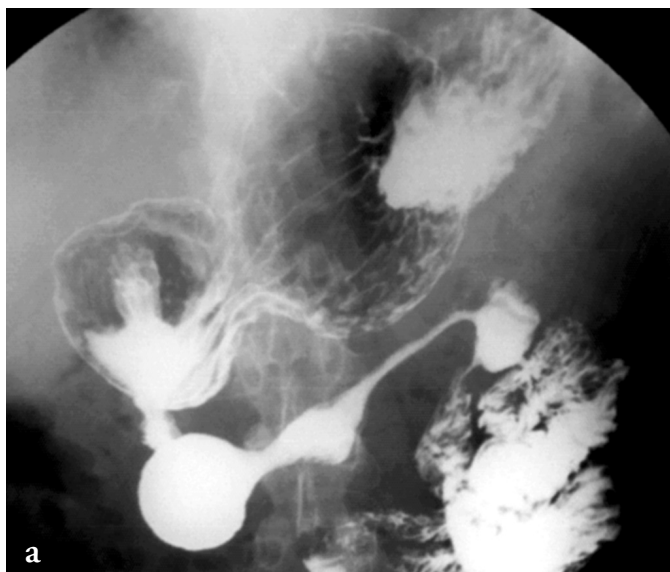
Before surgery: double contrast X-Ray shows duodenal segmental narrowings followed by dilatations up to the first jejunal loop with typical findings of Chron's disease.
